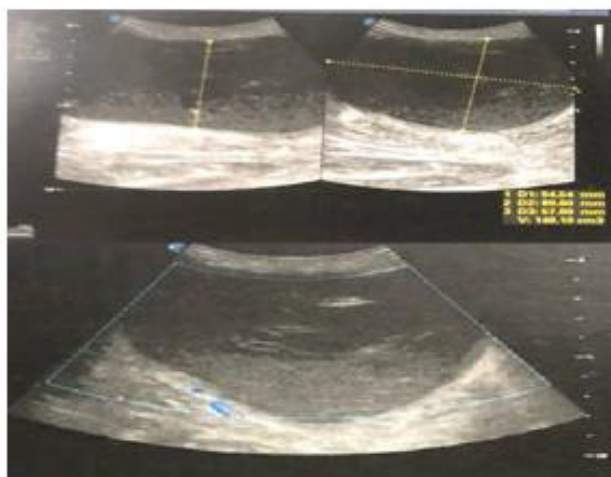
Ultrasound showing the hydatid cyst and its measurements.
